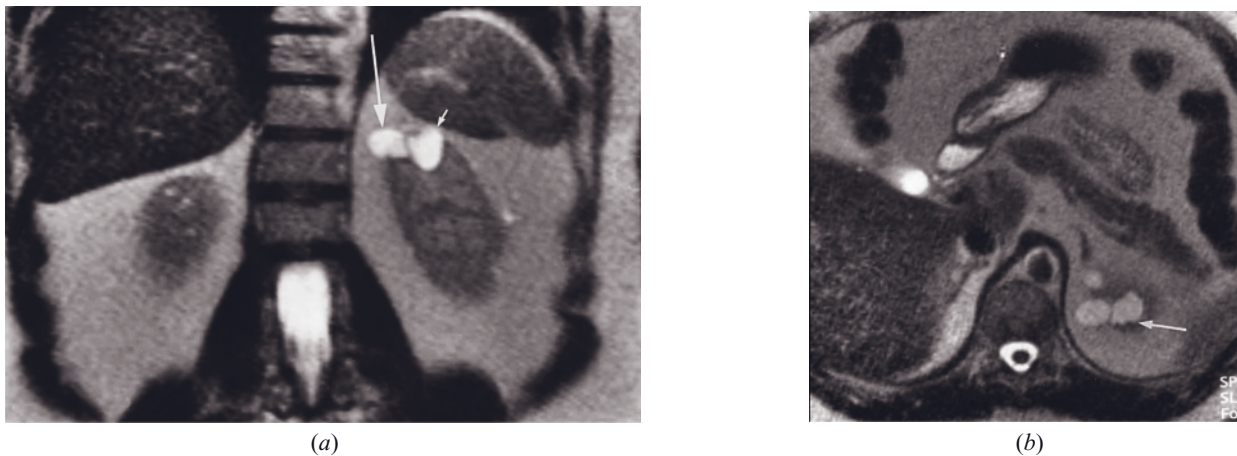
Calyceal diverticulum. Coronal (*a*) and transverse (*b*) T2-weighted SS-ETSE images. The coronal image demonstrates a calyceal diverticulum (small arrow, *a*) adjacent to a renal cyst (long arrow, *a*). The calyceal diverticulum extends to the surface of the kidney and contains low-signal-intensity milk of calcium, which is commonly observed in these lesions. Minute low-signal-intensity calculi are apparent in the dependent portion of the diverticulum (arrow) on the transverse image (*b*). Atrophy of the overlying renal cortex is apparent.
